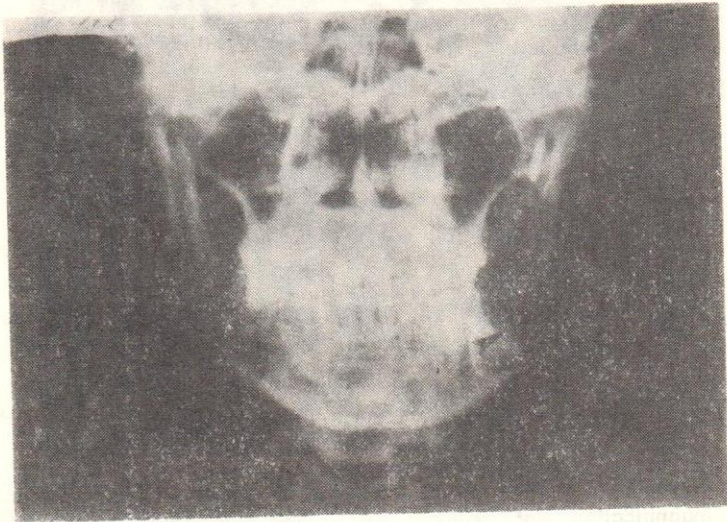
Radiograph taken after recurrence shows irregular osteolytic lesion and loss of the bone in both sides of the ramus (arrows).
